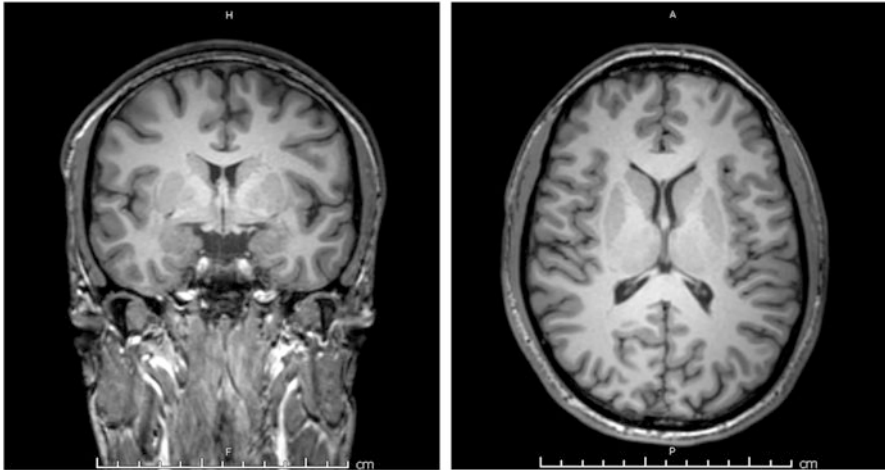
Magnetic resonance imaging (MRI), T1-weighted images
